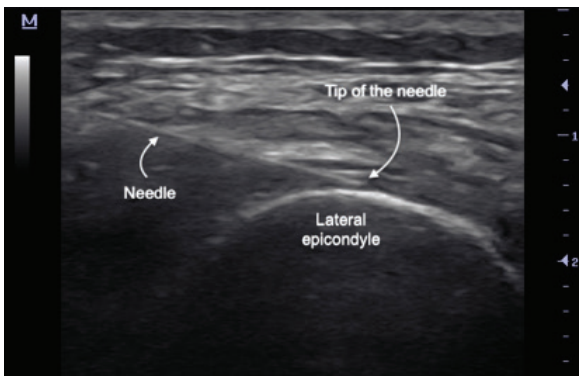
Ultrasound guided superior lateral genicular nerve block (axial plane)
